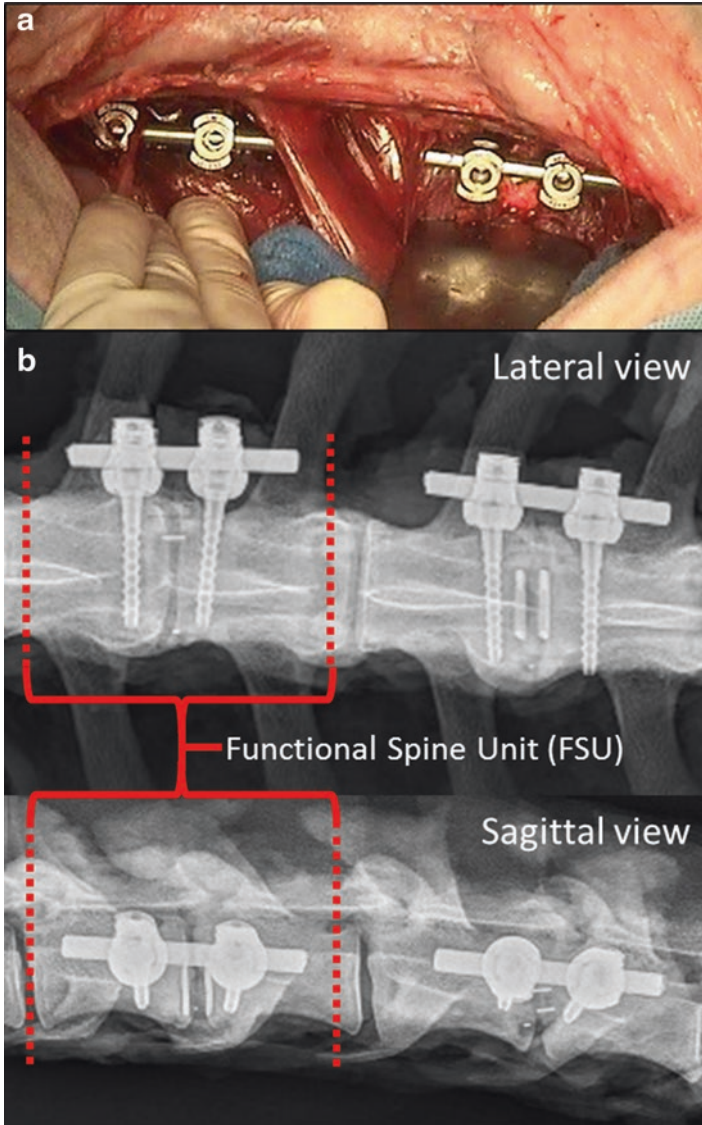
Implantation of FORZA PTC and FORZA PEEK at L2-L3 and L4-L5. (a) Surgical technique using a lateral retroperitoneal approach. Supplemental fixation was done as shown using the Orthofix FIREBIRD® pedicle screw system. (b) Lateral and sagittal post-surgery radiographs indicating each Functional Spine Unit (FSU)
